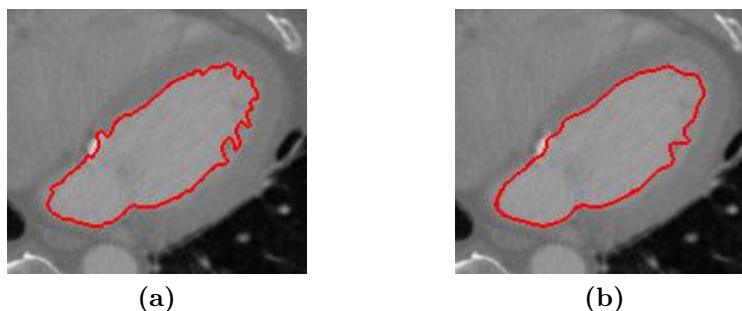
Influence of the RBF flatness (via parameter γ) on the smoothing of surface details – the cavities of the left ventricle and atrium are segmented as one object. (a) a relatively sharp RBF ($\gamma = 2$) captures the irregularities of the edge of the modelled object, while (b) a flat RBF ($\gamma = 6$) smooths the segmentation and produces a less detailed contour. This image is a central long-axis slice of a CT-scan of the heart.
